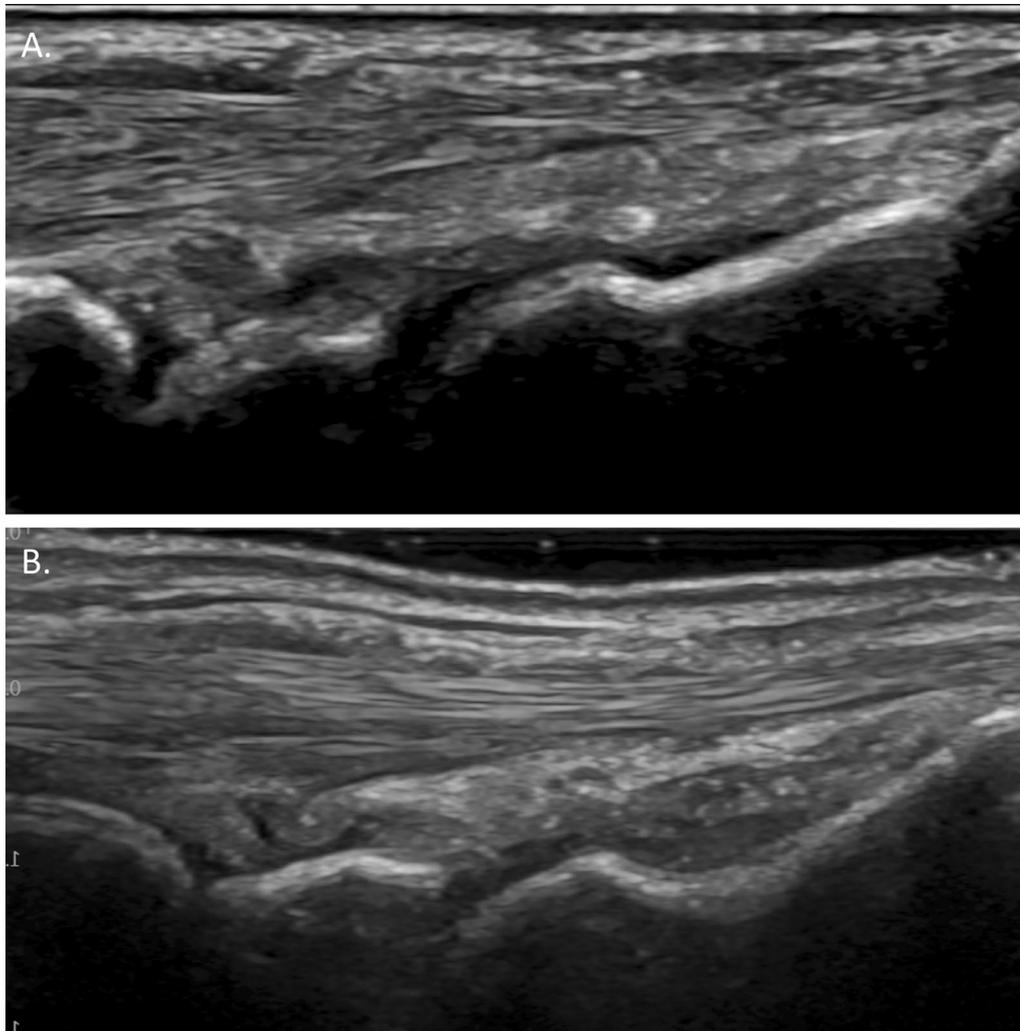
Representative grey scale ultrasound image of the wrist (radiocarpal and intercarpal joint) from the same patient by respectively ARTHUR (A) and the rheumatologist (B)
